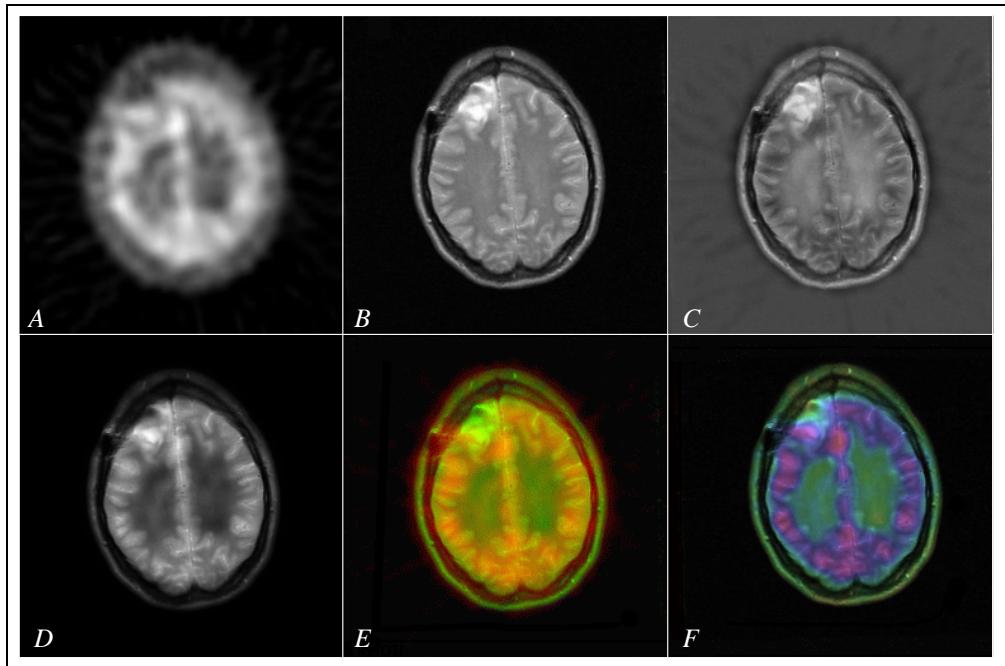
Non-selective integration of (A) original SPECT image and (B) original MRI-T2 image. Frames (C), (D), (E), and (F) are the (rescaled) integrated images of (A) and (B) with (C) MRI-T2 minus SPECT grey values, (D) SPECT multiplied with MRI-T2 grey values, (E) RGB integration; SPECT represented by a green color scale fused with MRI-T2 information represented with a red color scale, and (F) HSV integration; the hue component represents the SPECT data and the value component represents the MRI-T2 data.
